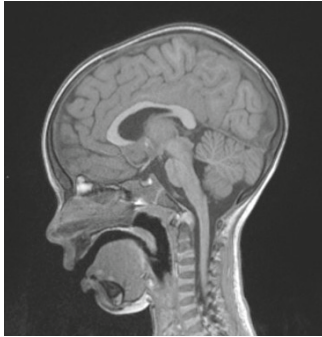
T1-weighted image.
